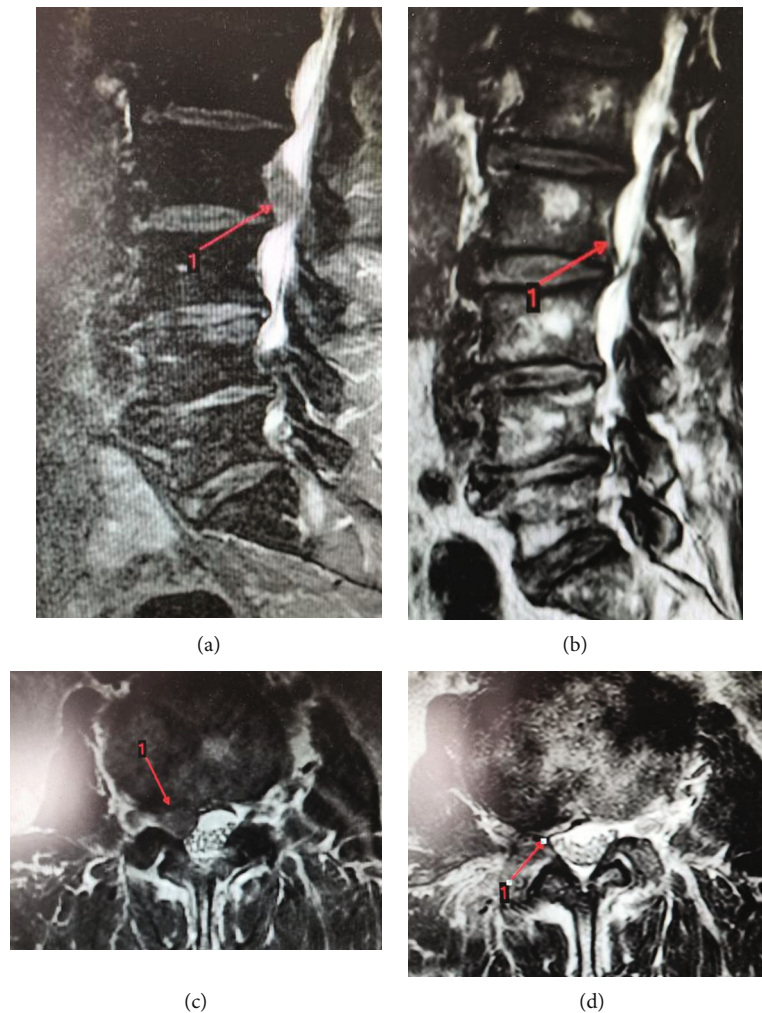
MRI imaging of typical case 1 (a: MRI sagittal of L2. Three intervertebral disc herniation before operation; b: MRI sagittal of L2. Three intervertebral disc after prolapse poroscopy; C: coronal MRI of L2. Three intervertebral disc herniation before operation; D: coronal MRI of L2. Three intervertebral disc herniation after prolapse poroscopy.).
